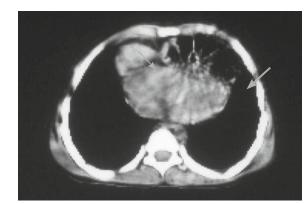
CT scan of a 9-month-old female child who sustained repeated attacks of chest infection showing bilateral Morgagni's hernia.
